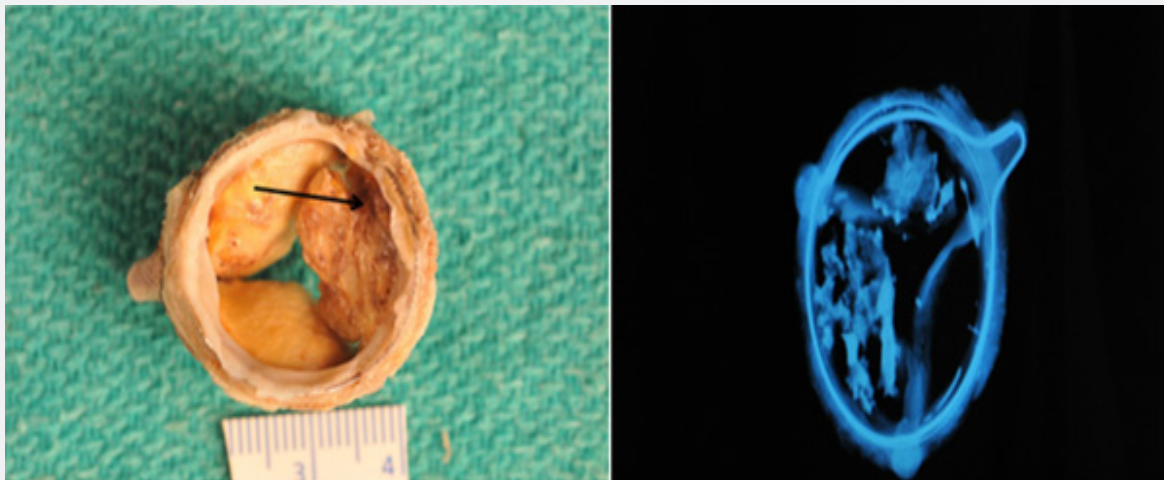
This pericardial bioprosthesis was explanted at 11 years. It shows areas of fine nodularity, and thickening, with one cusp showing more pronounced change and this cusp shows a large tear (arrow). B. Anteroposterior X-ray image shows marked calcification of 2 cusps (arrow).
